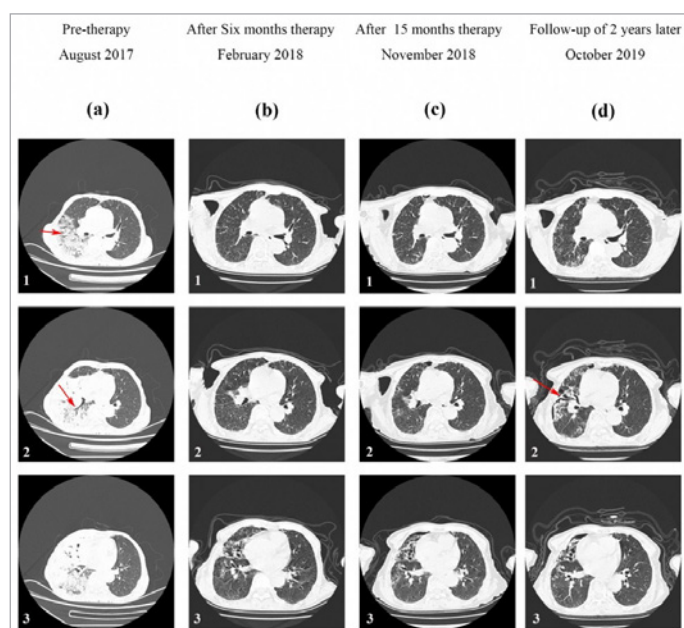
Pre- and post-therapy CT scan.
